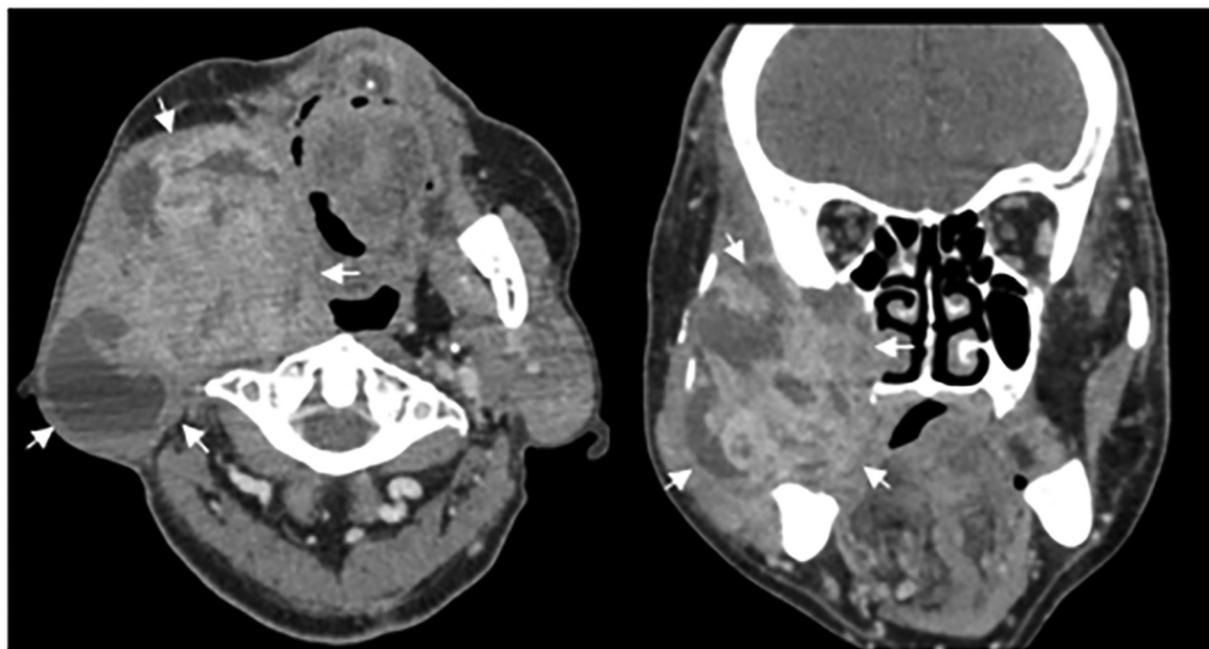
Contrast-enhanced CT images of the tumour. A tumour of 75 × 63 mm in size was present in the right parotid gland. The tumour was relatively well circumscribed and contained a low-density area. The arrows indicate the extent of the tumour.
